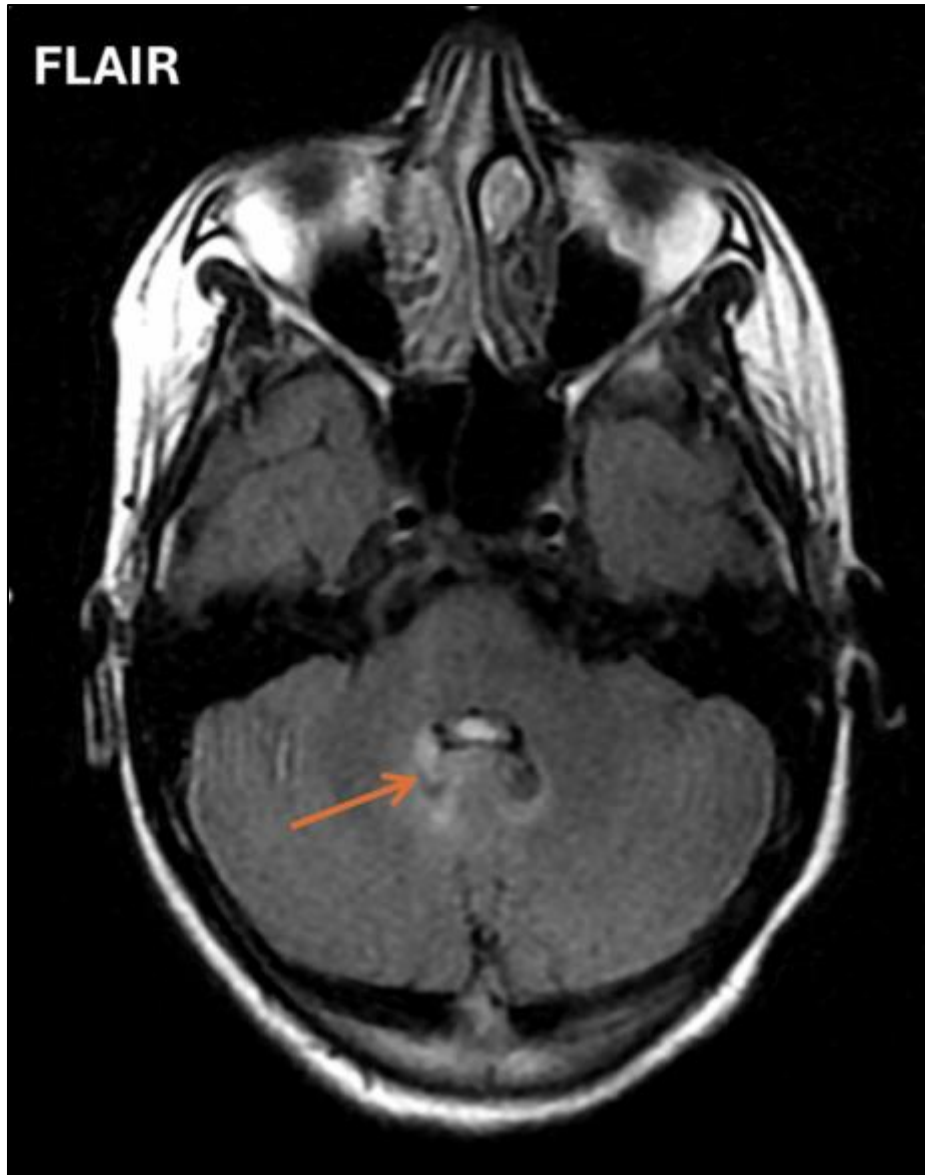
Initial Brain MRI
